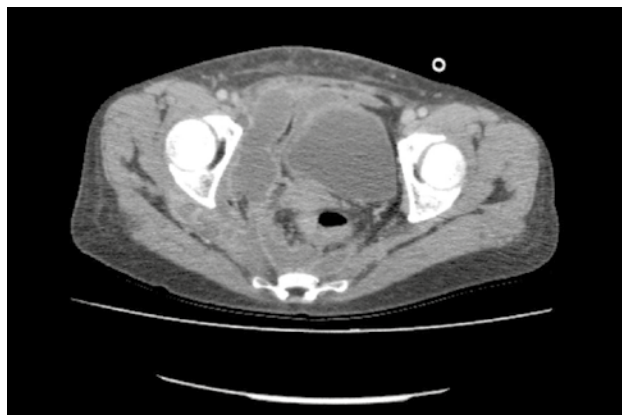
Axial contrast-enhanced CT image demonstrating posterior extension of the collection into the gluteal region.
